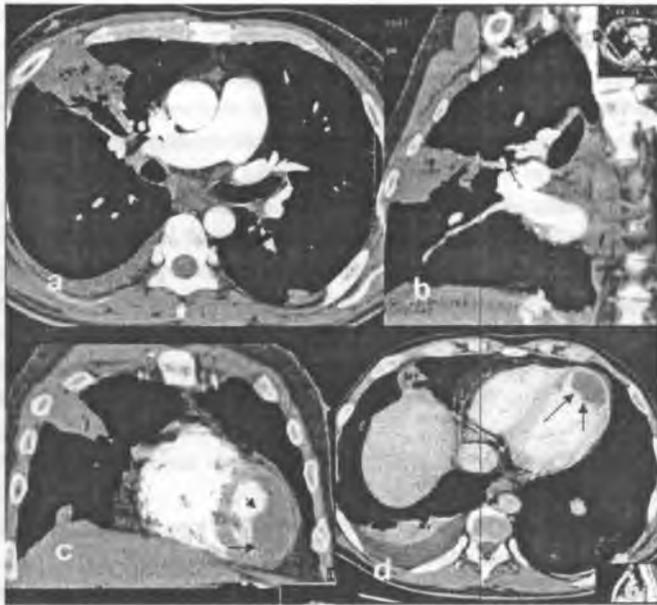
47-year-old male treated for acute lower limb ischemia caused by embolic occlusion of the popliteal artery. On the chest X-ray nodular lesion was found. MSCT showed signs of acute pulmonary embolism (a, b) and the large thrombus in the left ventricle close to the post-infarction scar of the anterior wall
